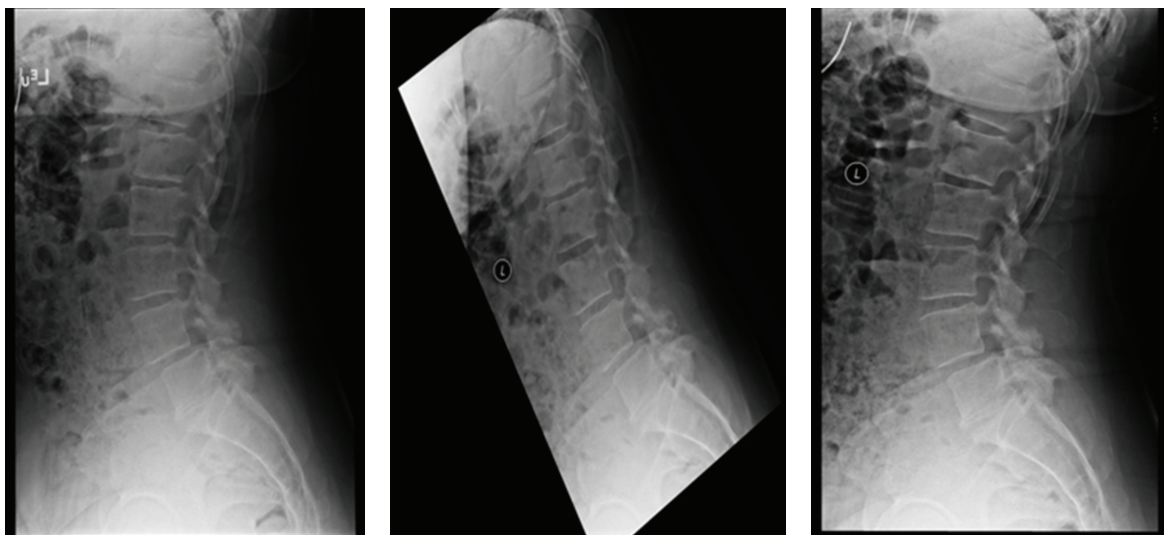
Lateral X-rays demonstrating a L4-L5 grade 1 spondylolisthesis. The standing lateral dynamic flexion and extension X-rays are used to determine motion at this segment.
